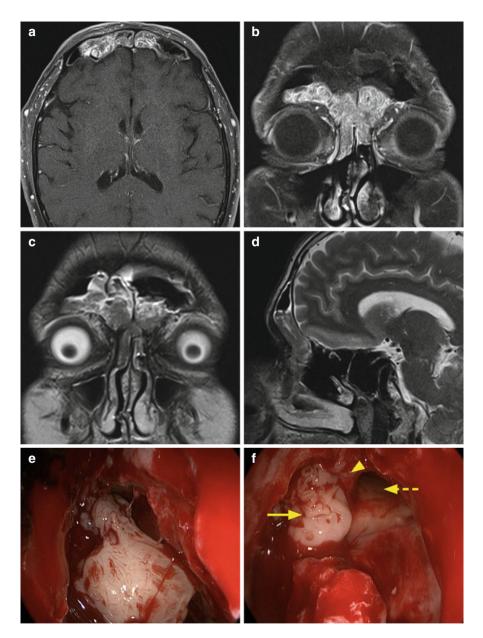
MRI images of a large bilateral frontal inverted papilloma with characteristic cerebriform appearance: (a) T1-weighted axial images with contrast. (b) T1-weighted coronal images with contrast. (c) T2-weighted coronal images without contrast. (d) T2-weighted sagittal images without contrast. (e) Intraoperative image of a portion of inverted papilloma removed from the left frontal sinus. (f) Intraoperative image of a remainder of the inverted papilloma filling the right frontal sinus (*arrow*), while the left one is free of disease (*broken arrow*), where the tumor extended, but did not attach. The frontal intersinus septum is preserved (*arrow head*)
